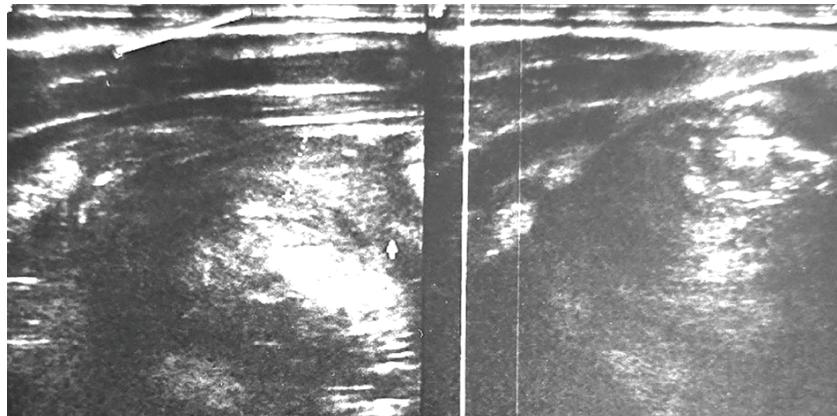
Abdominal ultrasound showing a hyperechogenic mass compressing the cecum, which had markedly thickened walls (6-7 mm)
